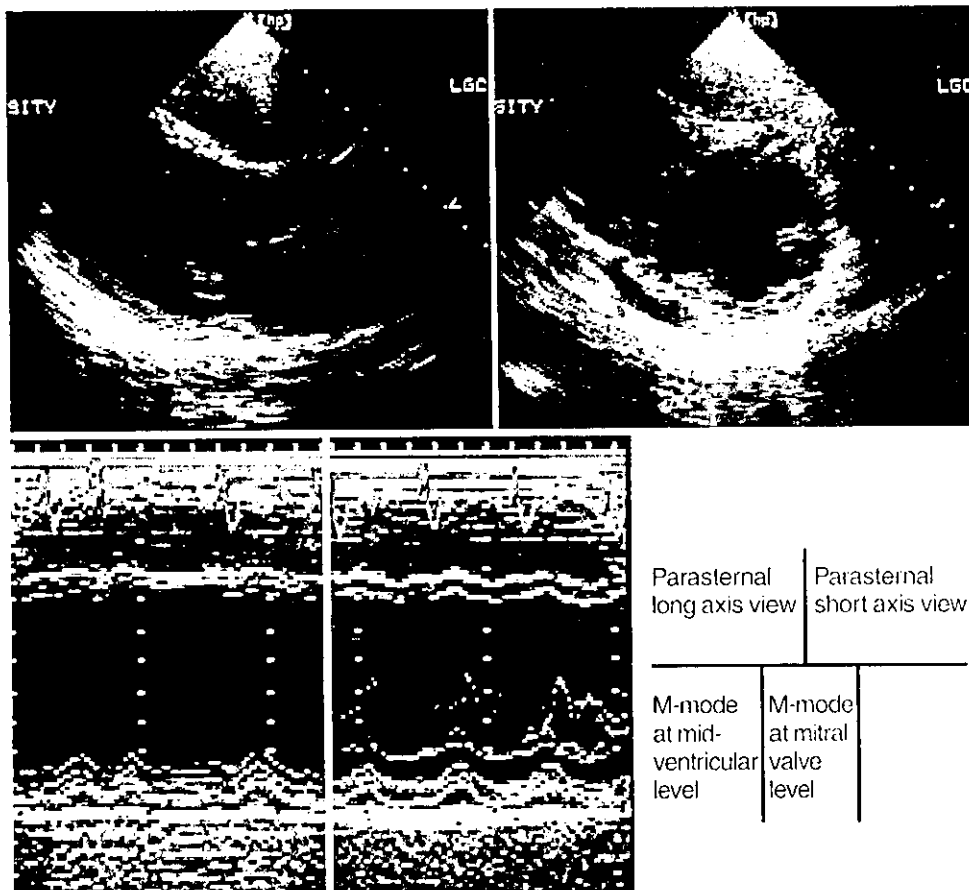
The echocardiography was performed on March 28, 2001. Parasternal long axis view on the left upper panel shows dilation of the left and right ventricles. Thinning of the left ventricular wall and a small amount of pericardial effusion are also observed on the right upper panel, the parasternal short axis view. The two lower panels are M-mode traces at the mid-ventricular level (left) and mitral valve (right). Both traces revealed reduced excursion and thinning of the left ventricular wall. The calculated ejection fraction of the left ventricle was 23% by the method of Pombo, suggesting marked reduction of left ventricular systolic function. B-B' step of mitral valve on the right lower panel suggests the elevation of left ventricular end-diastolic pressure.
